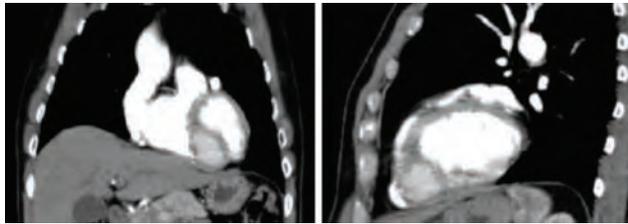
Computed tomography of the thorax.
